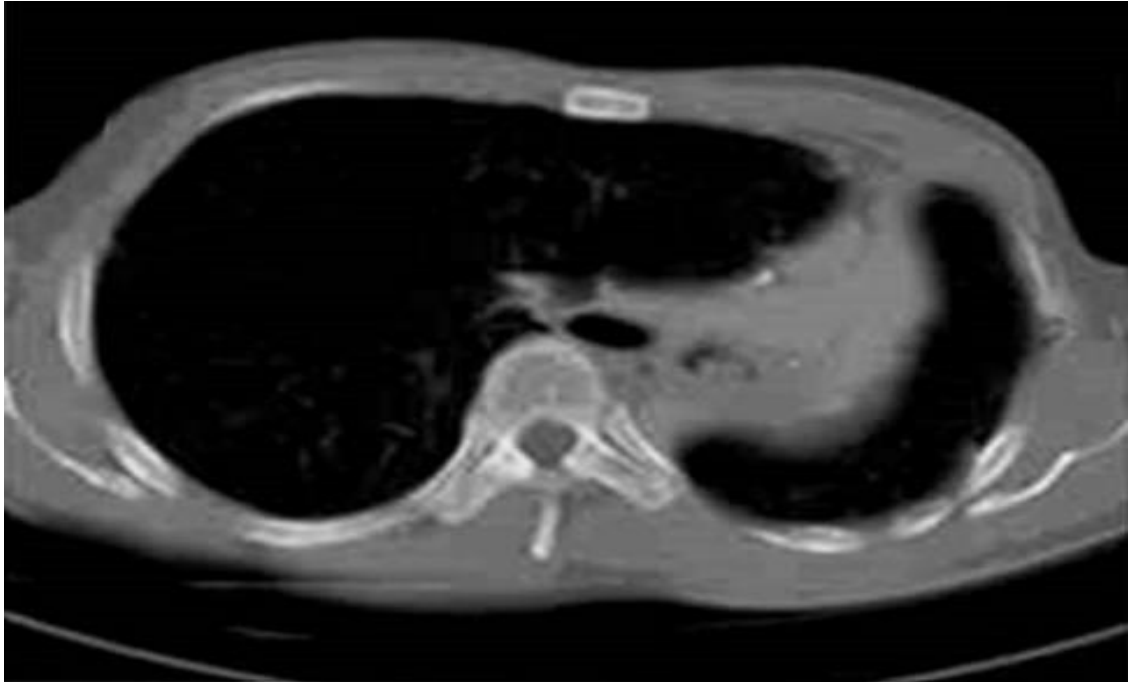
Chest computed tomography scan showing hypodense lesion around the left bronchus.
